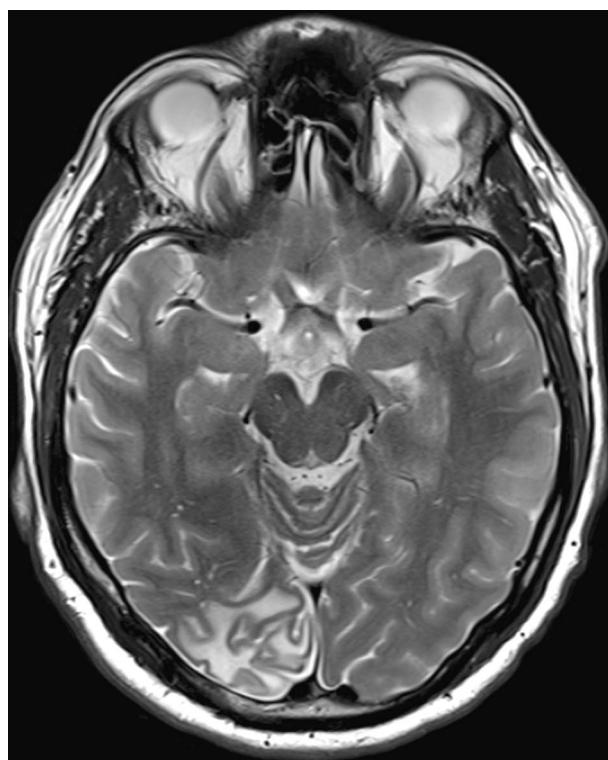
T2 axial magnetic resonance imaging 12 months after draining of brain abscess shows cortical atrophy of the right occipital lobe with moderate gliosis.
